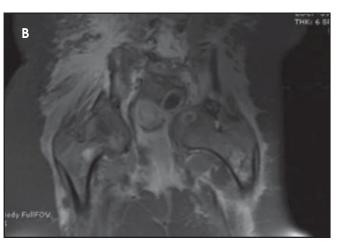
(A) Axial T2-weighted MRI of the pelvis with contrast demonstrates lymphatic malformation of the right intertrochanteric region measuring approximately 6 mm (arrow). (B) Coronal T1-weighted MRI reveals extensive lymphatic malformation. Involvement of the right intertrochanteric lesion is appreciated (arrow).
